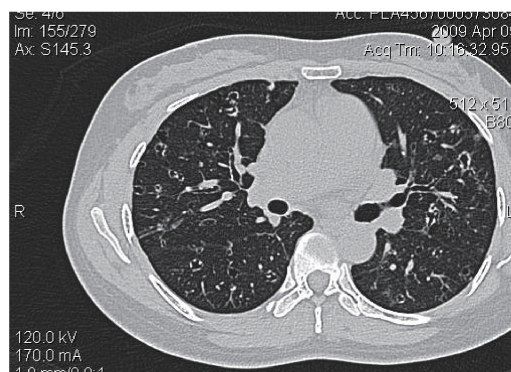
Chest CT showed multiple small thin-walled cysts uniformly distributed in bilateral lungs
